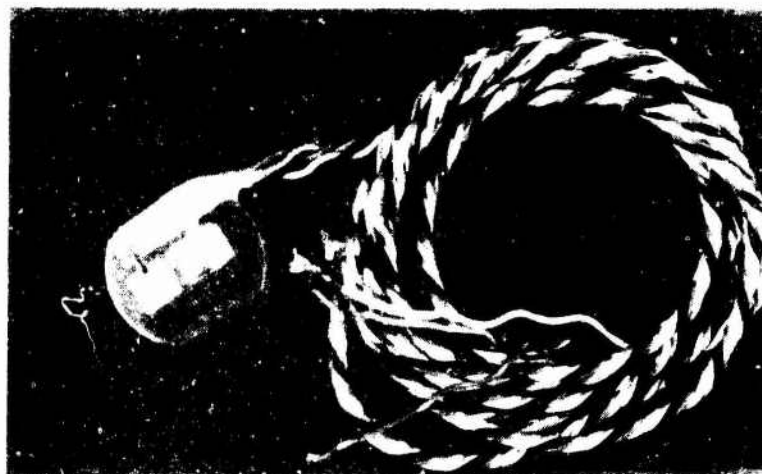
Doppler flowmeter transducers, perivascular type, with polystyrene molded bodies and PVC-insulated leads, for surgical implantation on selected vessels for flow measurement and embolism detection.
